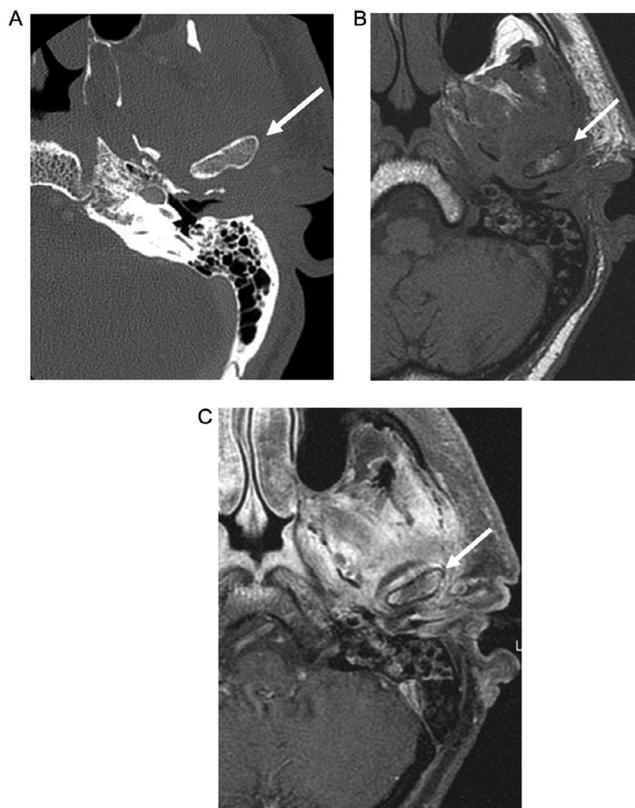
75 m h/o diabetes with fungal infection extending from the EAC into the TMJ. Axial CT (A) shows no evidence of erosion of the mandibular condyle (arrow). Axial T1W image (B) shows decreased signal replacing normal hyperintense fatty marrow (arrow). Axial postcontrast T1W image with fat saturation (C) shows corresponding marrow enhancement (arrow).
